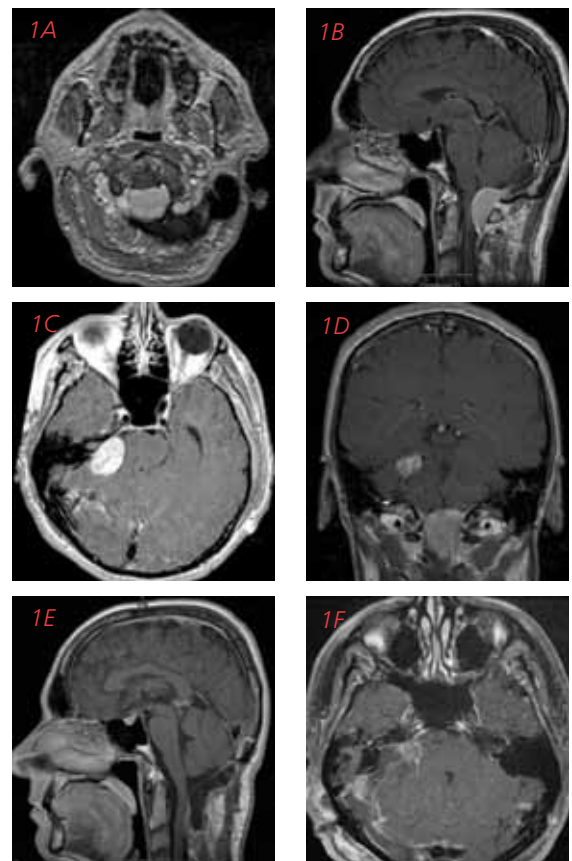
Magnetic resonance images of a 45-year-old man with the mosaic form of NF2. He presented with diminished hearing and the presence of a foramen magnum meningioma as well as a unilateral acoustic schwannoma (A, B, C, D). He was found to have multiple small spinal neurofibromas on further imaging (not shown). Both lesions were sequentially removed without morbidity (E, F). The acoustic tumor was removed via a retrosigmoid approach with successful preservation of residual hearing and normal cranial nerve function. Used with permission from Barrow Neurological Institute and PMPH-USA, Ltd.
